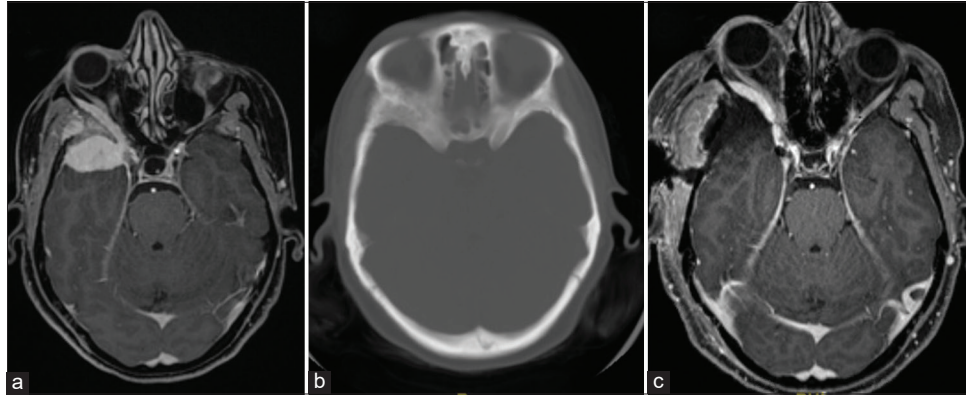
Case 2. (a) Preoperative T1-weighted postgadolinium administration MR images demonstrating right SOM extending into the right orbit and cavernous sinus. (b) Preoperative CT head demonstrating hyperostosis. (c) Postoperative T1-weighted postgadolinium administration MR images demonstrating intraorbital residual lesion approaching the superior orbital fissure.
